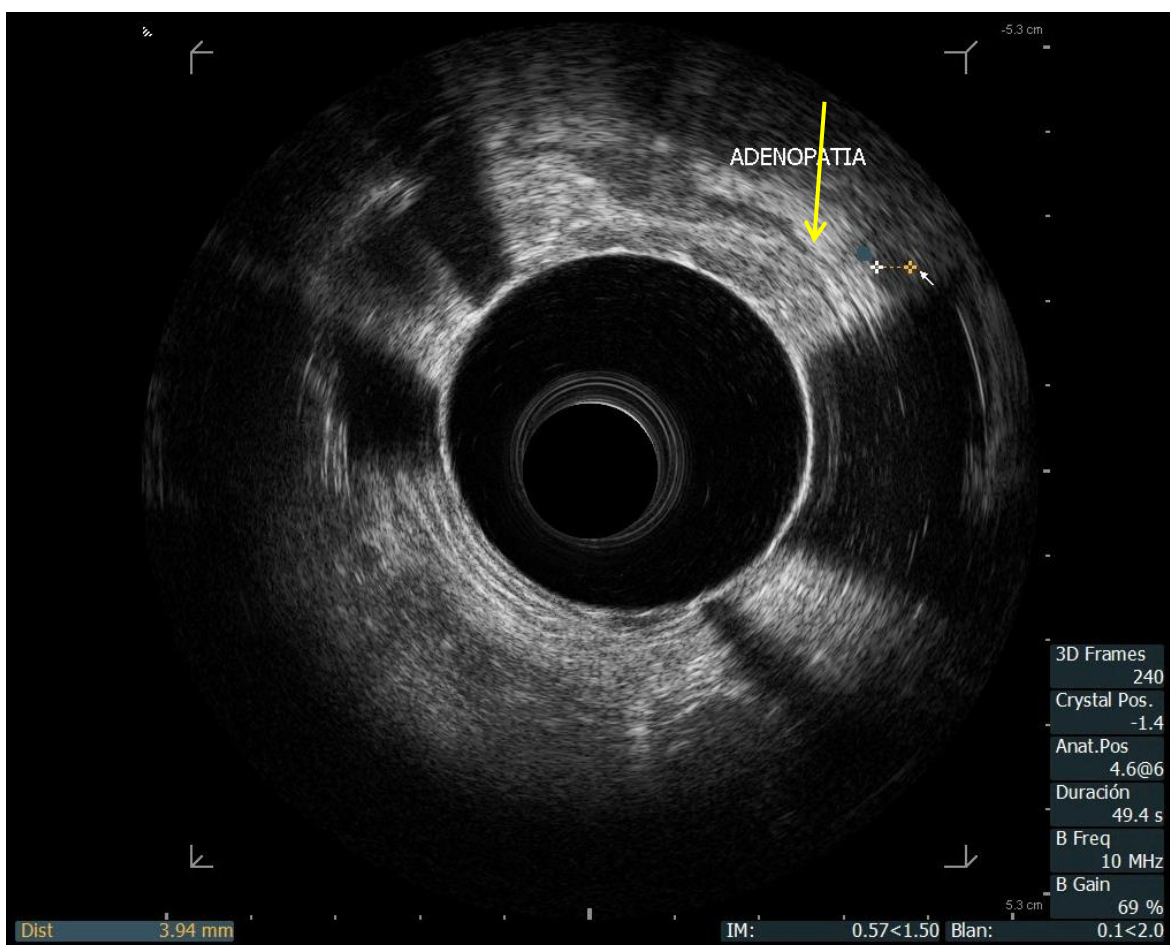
(Case 202) Endoscopic ultrasound (EUS) in the same 65-year old patient which showed a mid-rectal hypoecogenic lesion that affected the perirectal fat, with one pathological lymph node (yellow arrow) and classified as an uT3N1a tumour. However, the test was unsatisfactory due to the stenotic nature of the lesion, a common shortcoming of EUS. The MRI performed showed a cT3bN2b with a threatened mesorectal fascia
